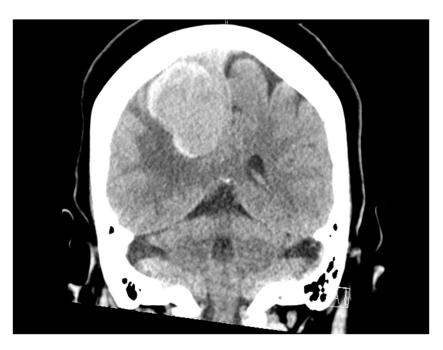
Computed tomography (CT) scan of the brain in coronal view revealing a dural-based right parietal hyperdense mass with surrounding edema, compression of the right lateral ventricle's atrium and a right-to-left midline shift.
